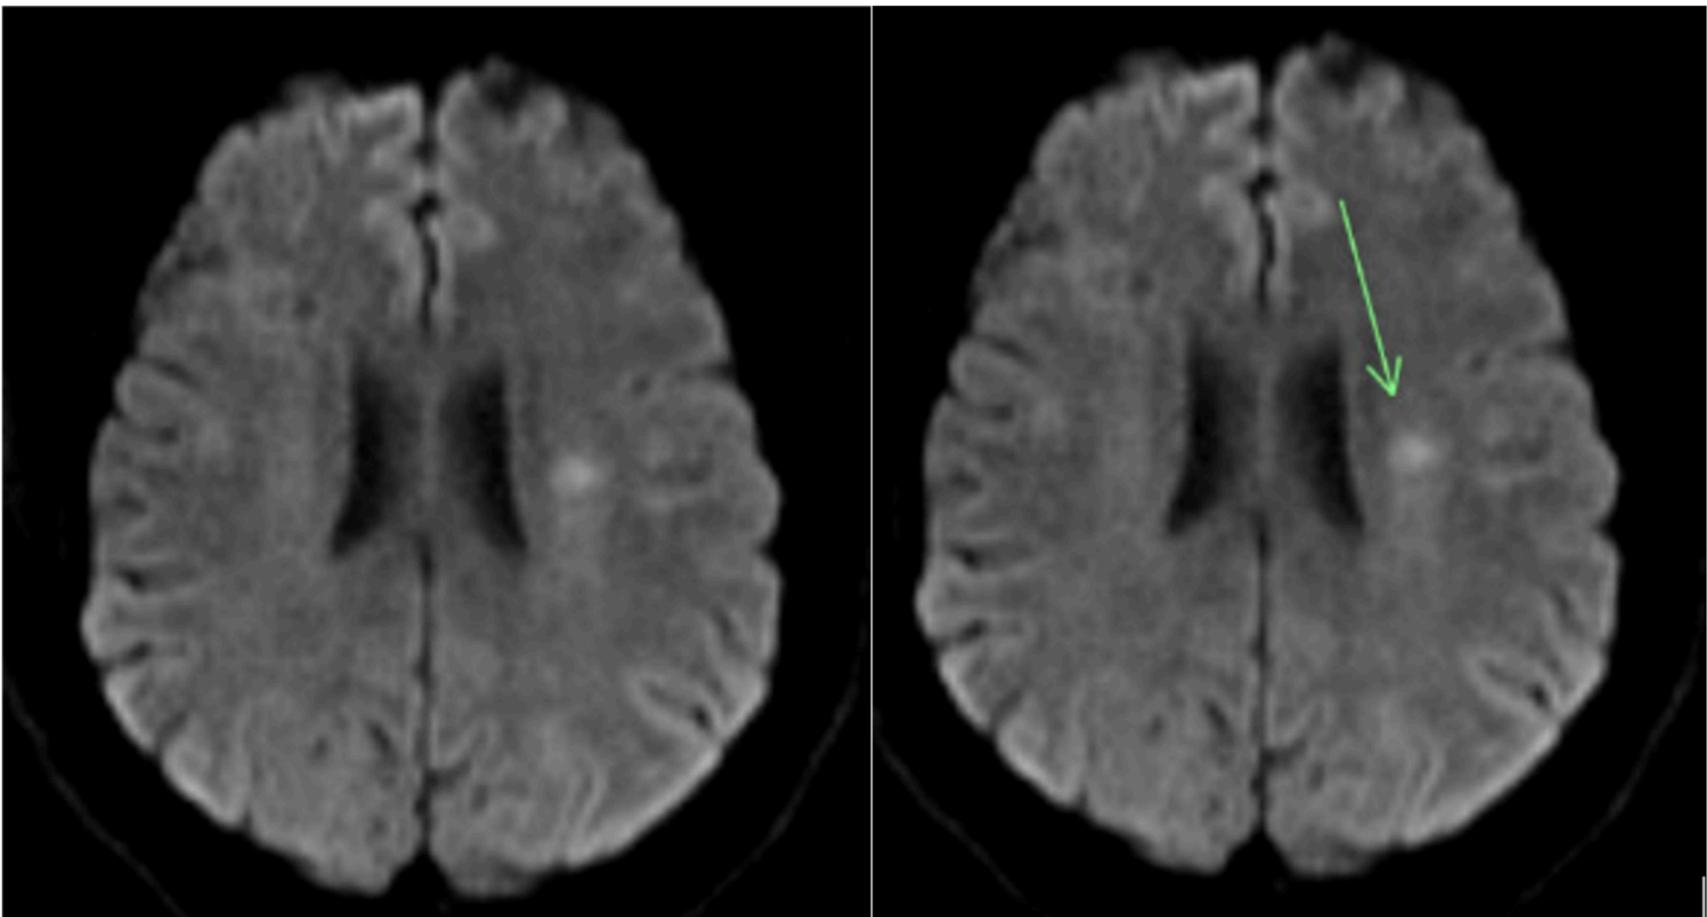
Follow-up diffusion-weighted magnetic resonance imaging brain images after a negative non-contrast head computed tomography (CT) scan and contrast enhanced CT angiogram of the neck show a small acute ischemic infarct in the left corona radiata.
